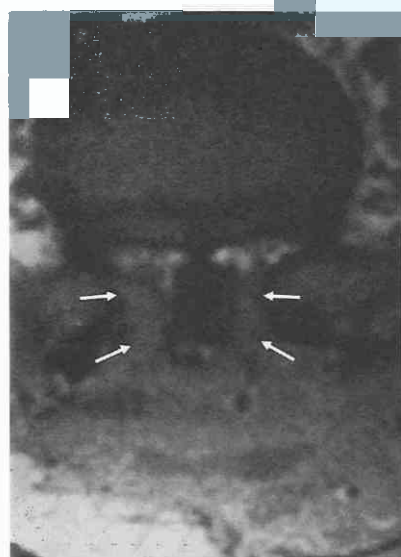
Axial T1-weighted MR image shows an epidural scar (*arrows*) partially encircling and compressing the thecal sac. The posterior margins of the scar are ill defined.
